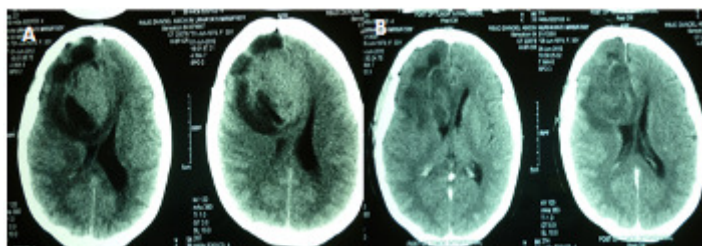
CT scan result when the Glioblastoma is recurring (A) compared to the post op result (B)
